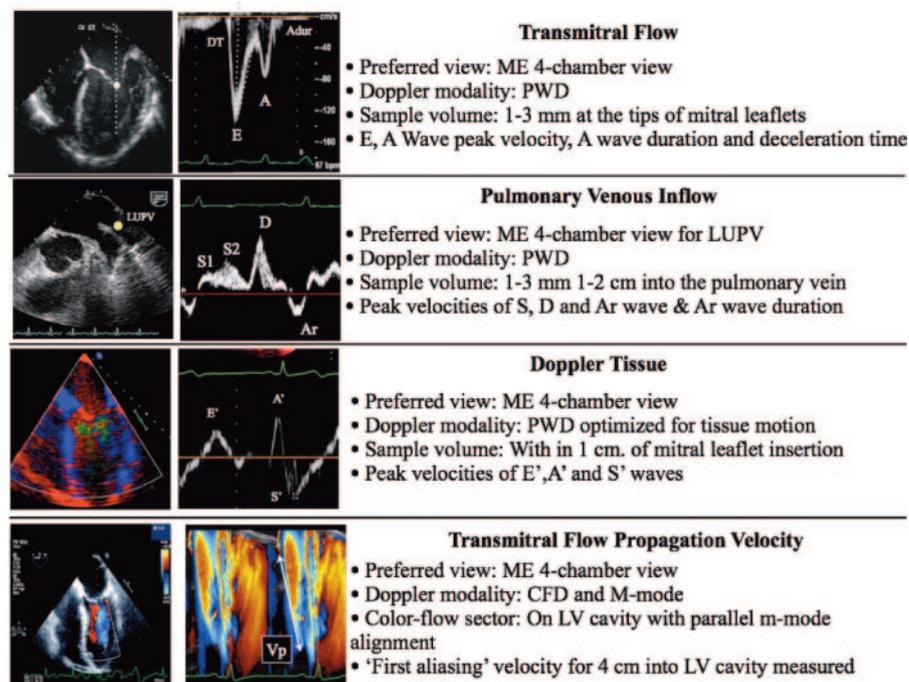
Doppler modalities for assessment of myocardial diastolic function. PWD = pulse wave Doppler; DT = deceleration time; Adur = A-wave duration; ME = midesophageal; LAA = left atrial appendage; LUPV = left upper pulmonary vein; CMM = color M-mode; DTI = Doppler tissue imaging; Ar = atrial reversal wave; RV = right ventricle.
